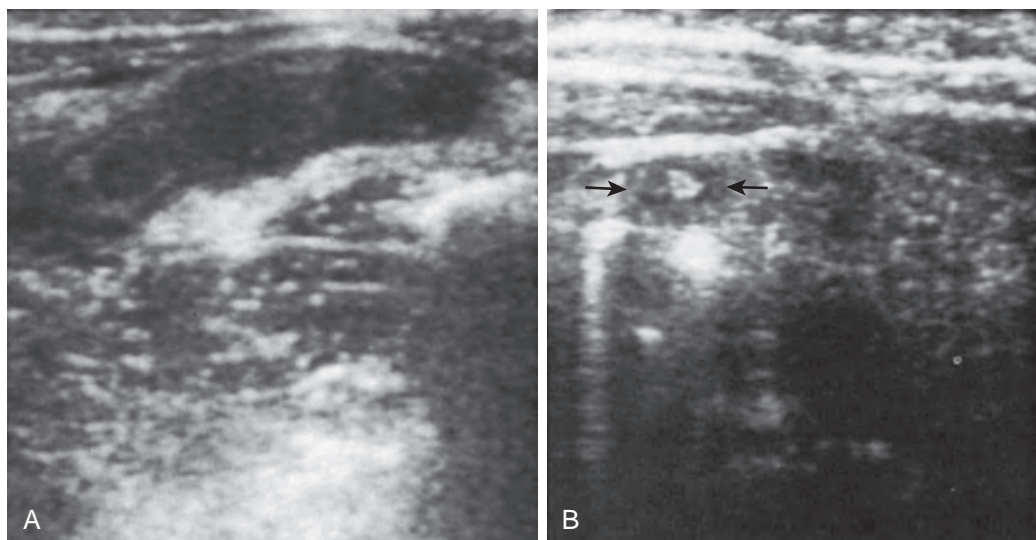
Sonography of appendicitis. A. A dilated, incompressible appendix lies beneath the abdominal musculature on this longitudinal scan. B. Transverse scan of the right lower quadrant in a different child shows a widened appendix (arrows), suggesting appendicitis. The echogenic focus in the center causing distal shadowing is an appendicolith.
